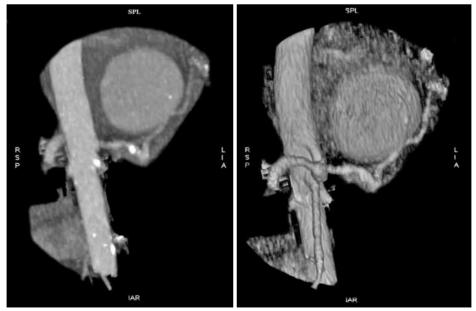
In the early arterial phase, computed tomography revealed a 5x6 cm mass in the abdominal area that had an isodense appearance when viewed with the contrast agent. In addition, an intraperitoneal hematoma filling the gap between the spleen and stomach can also be seen.
